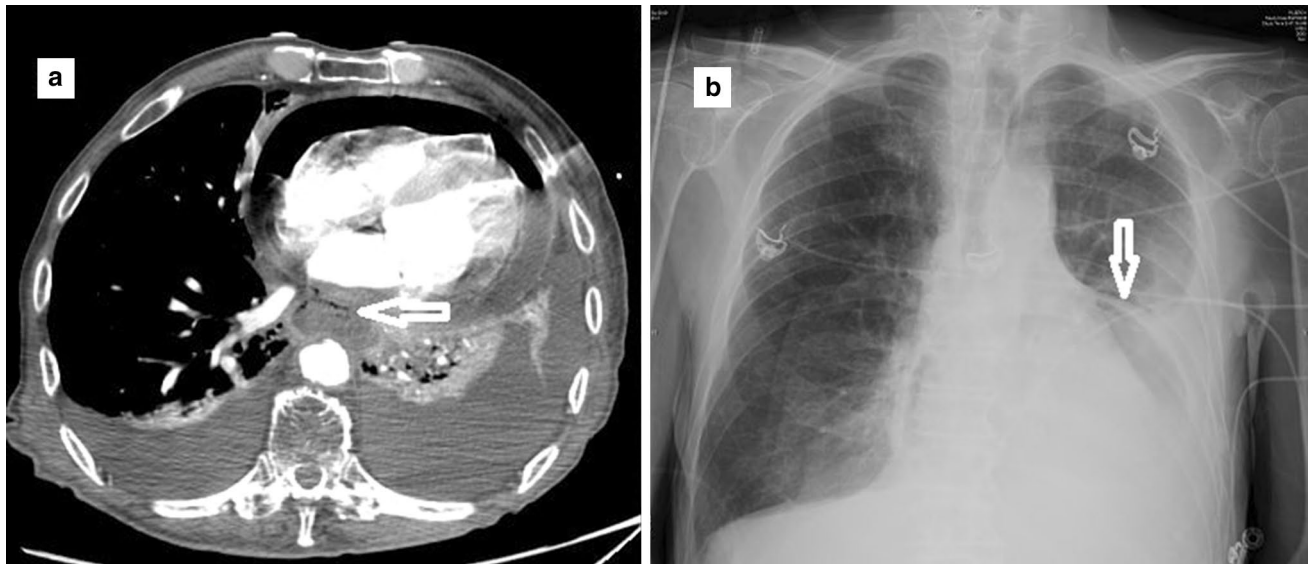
a Chest X-ray study showing a large left-sided pleural effusion with air inside the pericardial sac (marked by arrow). b CT scan of chest (axial view) showing the fistula (marked by arrow) between the esophagus and posterior wall of the pericardium with hydropneumopericardium
